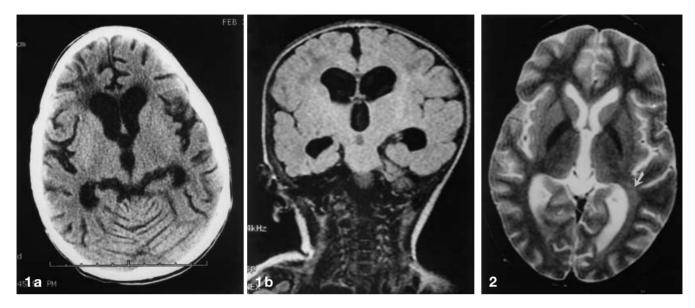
Axial CT (a) and coronal T1-weighted MR (b) images demonstrate parenchymal atrophy with ventricular dilatation out of proportion to sulcal atrophy in an HIV positive child
